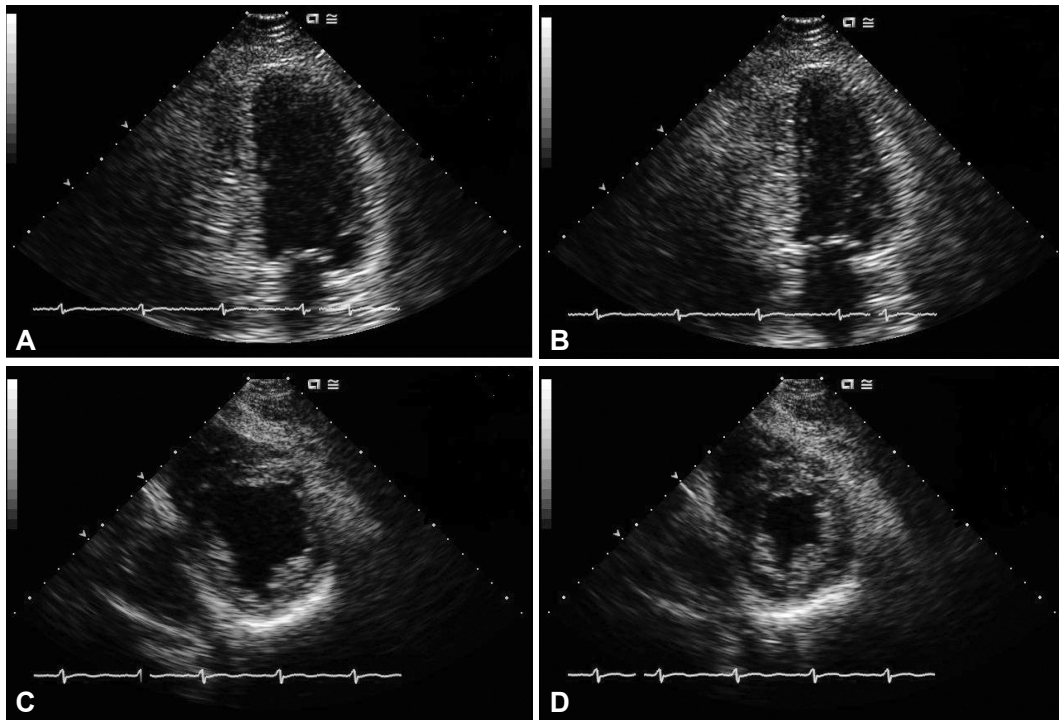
Follow-up transthoracic echocardiogram demonstrates significantly improved LV systolic function and dilatation together with complete resolution of LV thrombus. A: end diastolic period on apical 4-chamber view. B: end systolic period on apical 4-chamber view. C: end diastolic period on PSAX mid-ventricular view. D: end systolic period on PSAX mid-ventricular view. LV: left ventricle, PSAX: parasternal short axis.
